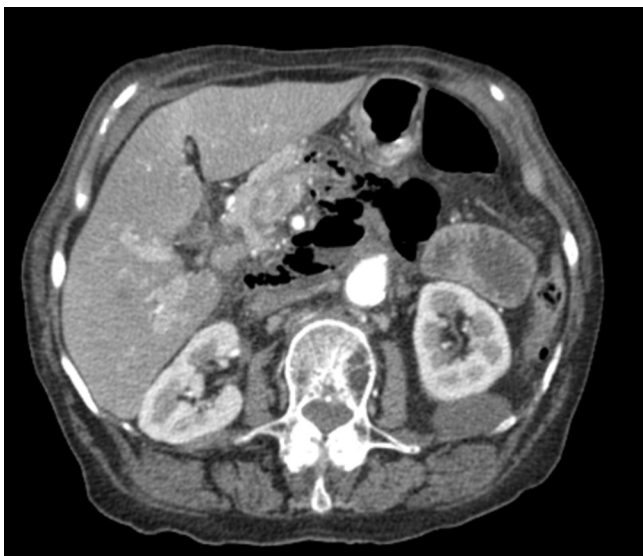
CT scan evidencing a retroperitoneal perforation with retroperitoneal free air.
